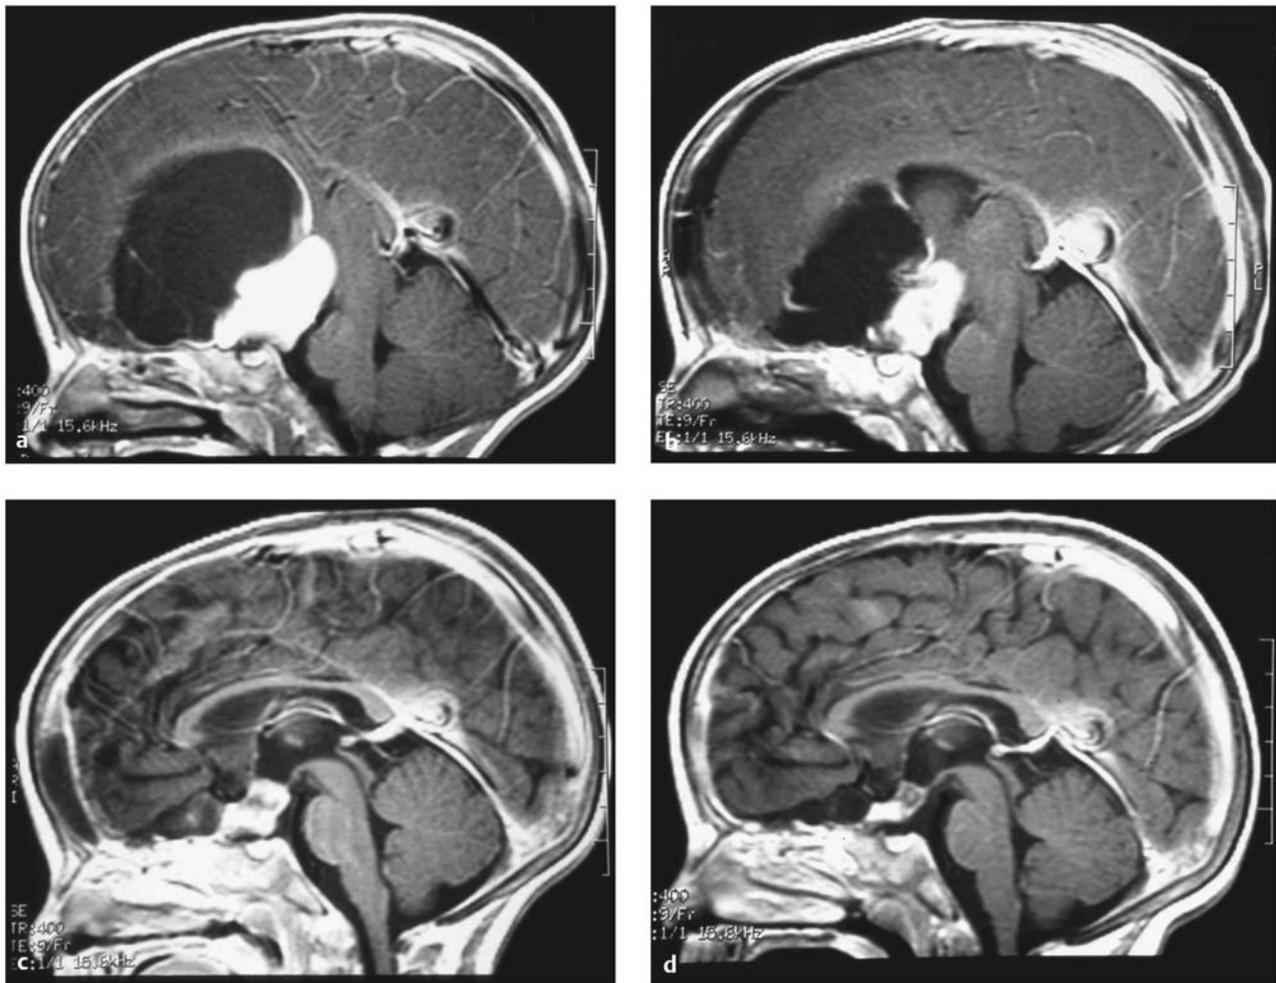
Sagittal magnetic resonance imaging after gadolinium (a) at diagnosis, (b) following surgery, (c) at 3 months, and (d) at 12 months after treatment with carboplatin and vincristine in an 11-month-old child without neurofibromatosis with a diencephalic pilocytic astrocytoma.
